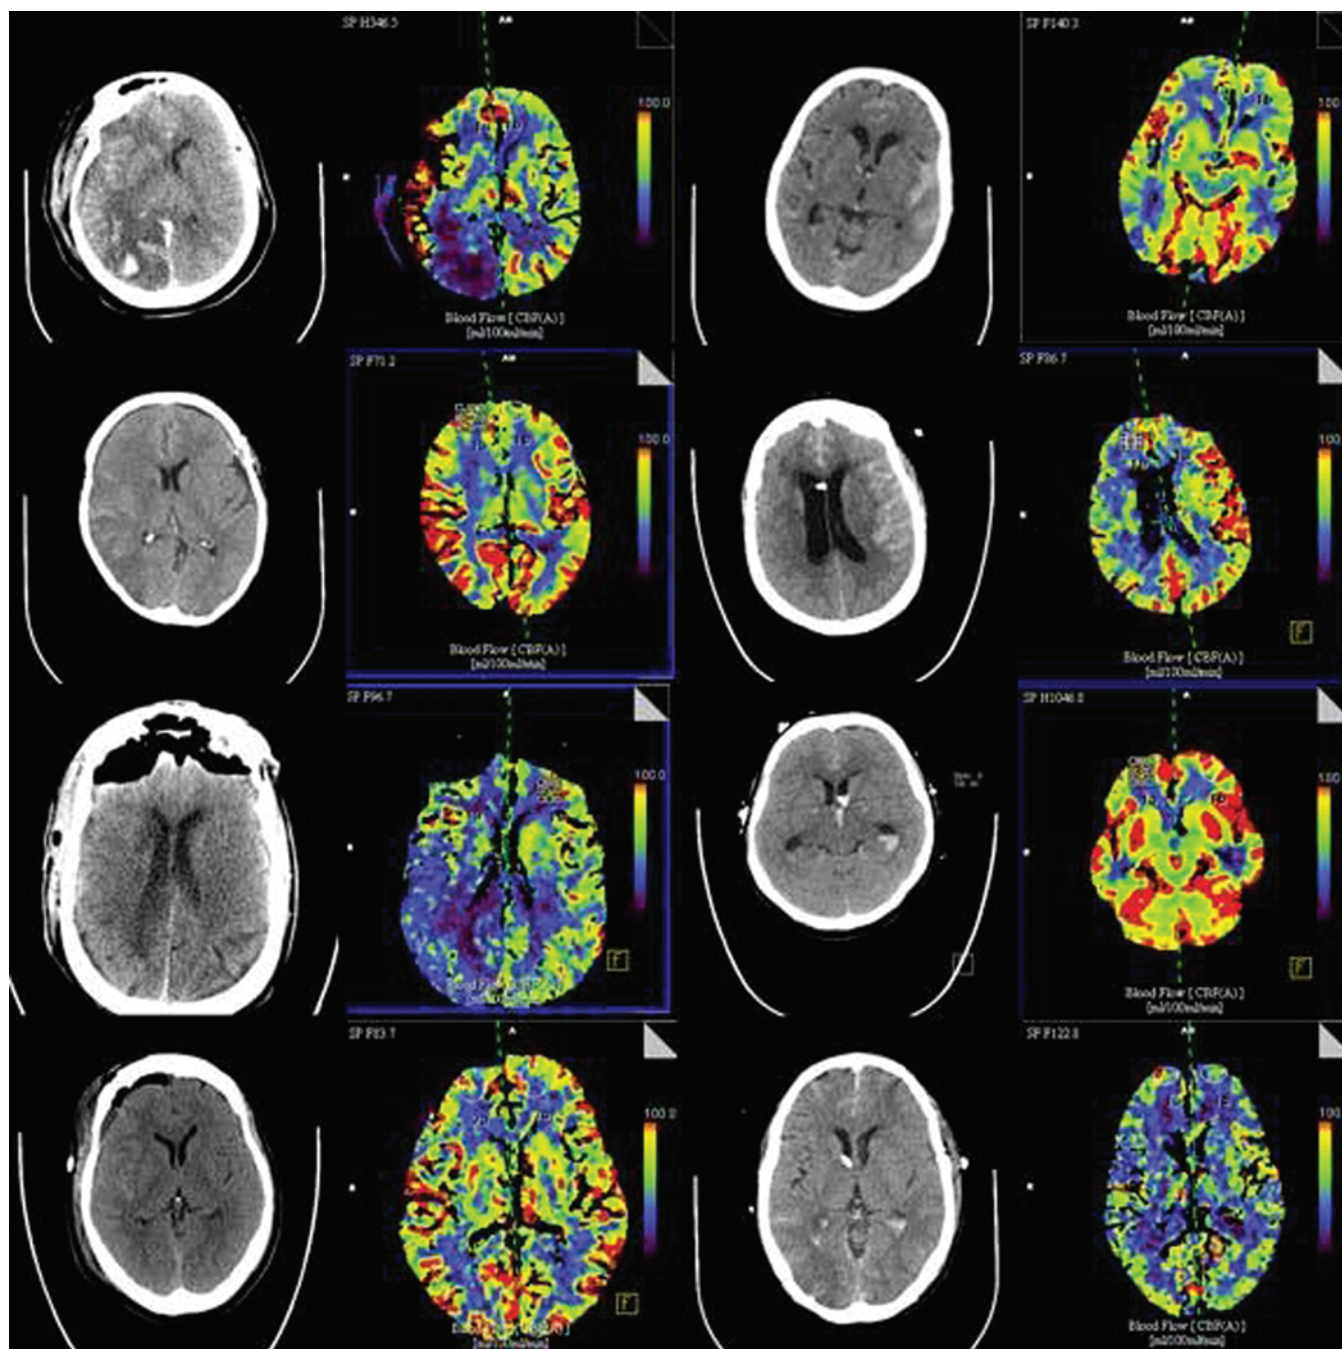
Axial CT head and CT perfusion images of all 8 patients included in the study.
